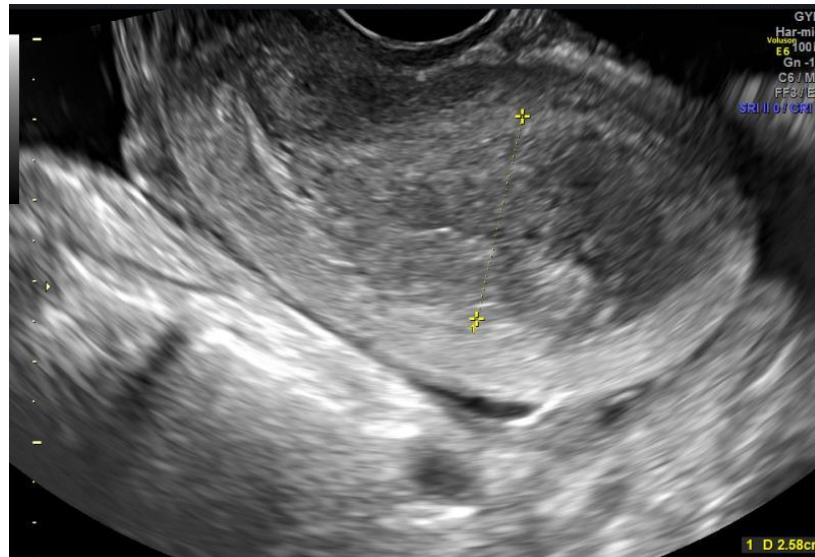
ultrasound showing empty uterus with thickened endometrium.
